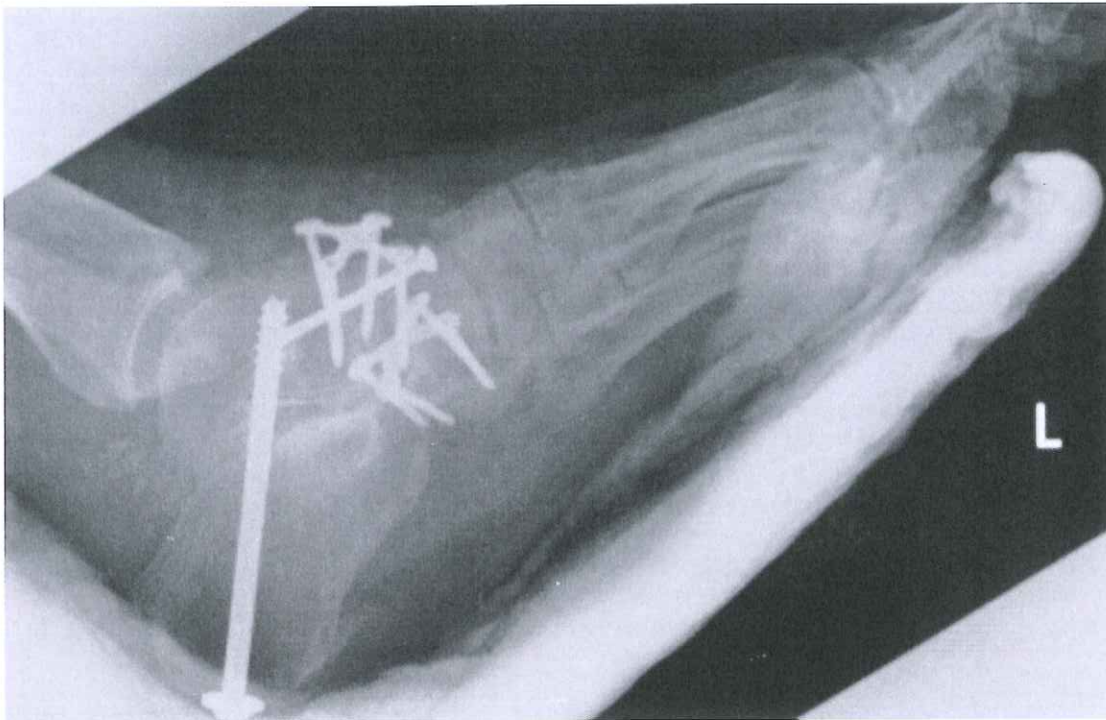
X-ray showing the medial view of the left foot after surgery.
